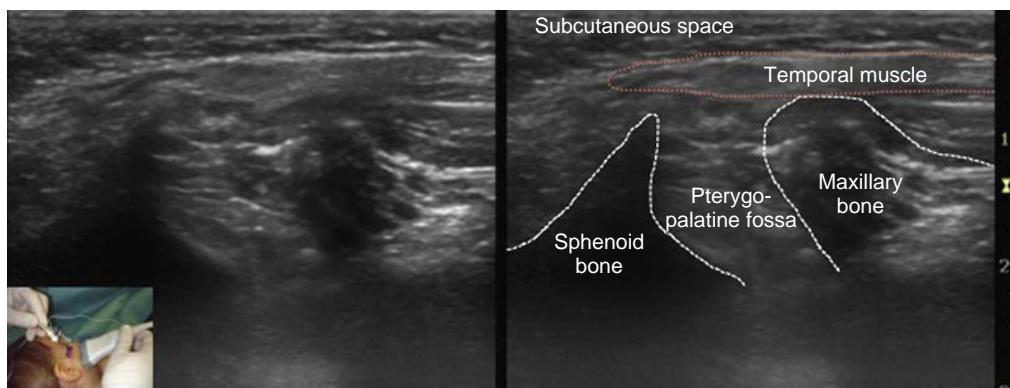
Ultrasound imaging of suprazygomatic maxillary nerve block.
